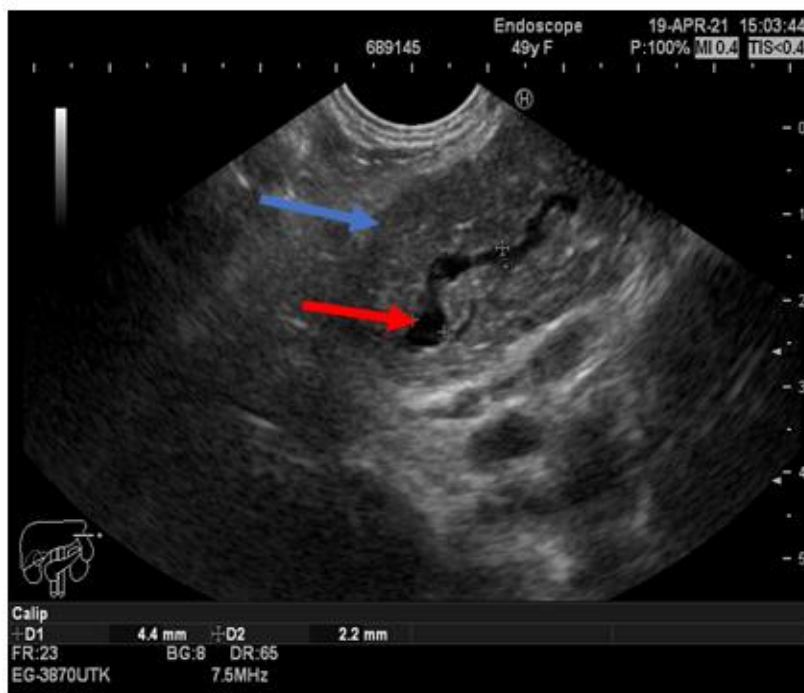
Ultrasound endoscopic appearance of the sinuous aspect of the Wirsung (red arrow) and the lobulated aspect of the pancreas (blue arrow)
